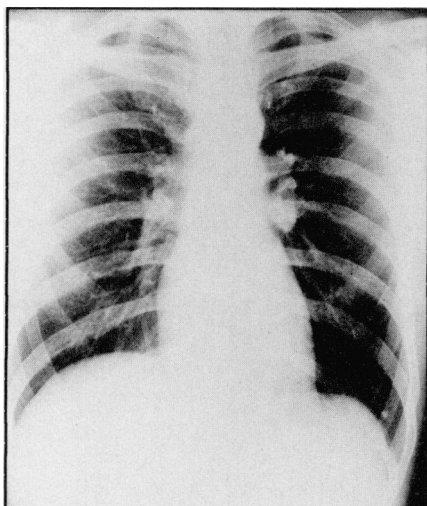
Chest roentgenogram of an 18-year-old black male, showing left hilar adenopathy with calcific change. This patient also had calcifications in the region of the spleen on abdominal films. Healed primary histoplasmosis
